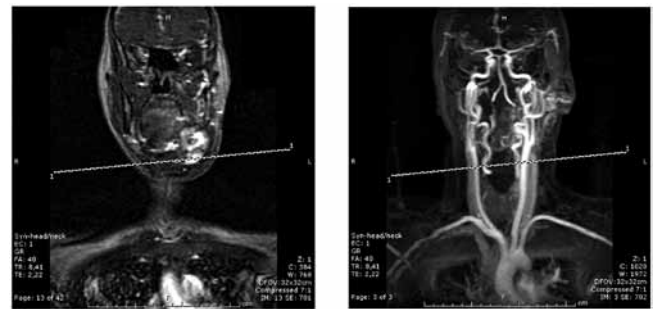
Subtotal closure of the AVM on MRI and MRA performed the day after embolization.
